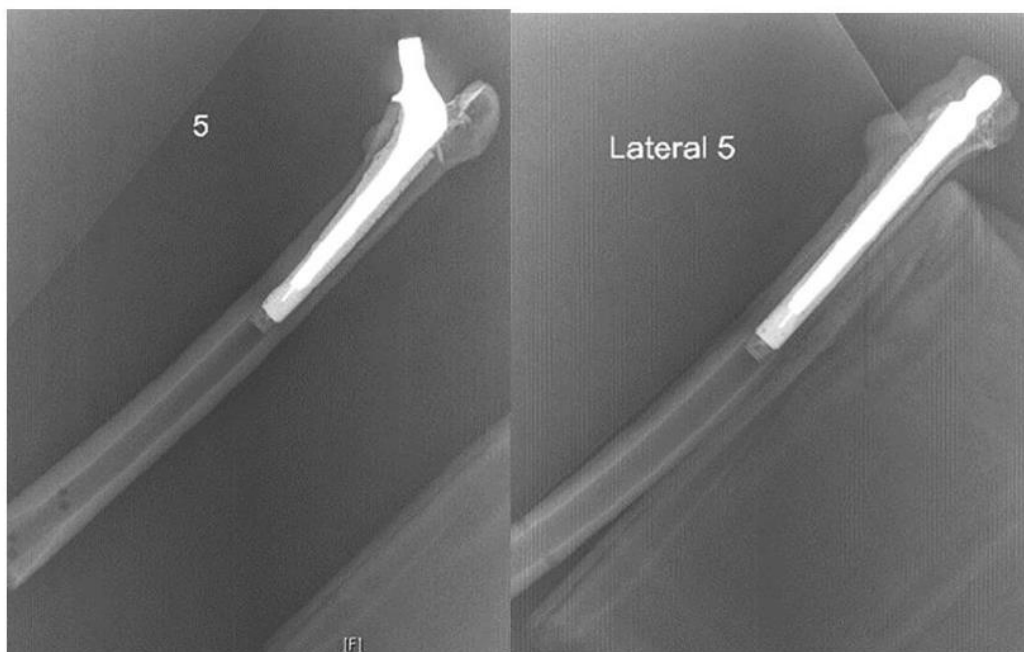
AP and Lateral radiographs of experimental models to evaluate for cement mantle defects
